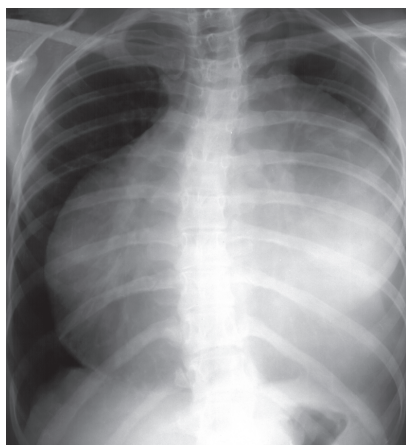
Frontal X-ray. Spherical configuration of the heart
